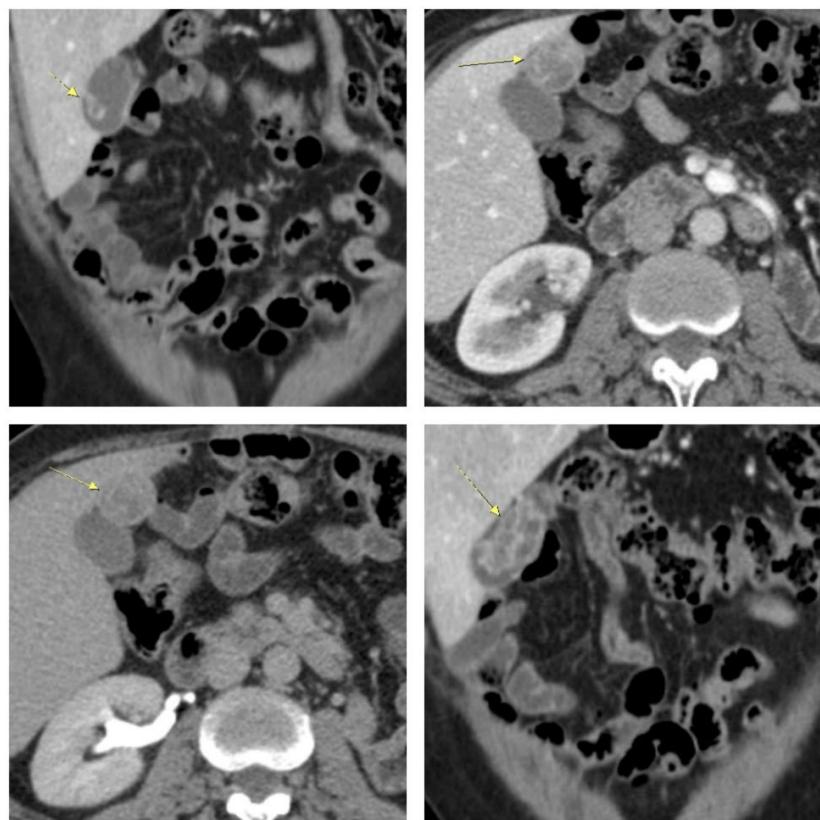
Contrast-enhanced CT scan showing hypervascular polypoid lesions in the gallbladder.
